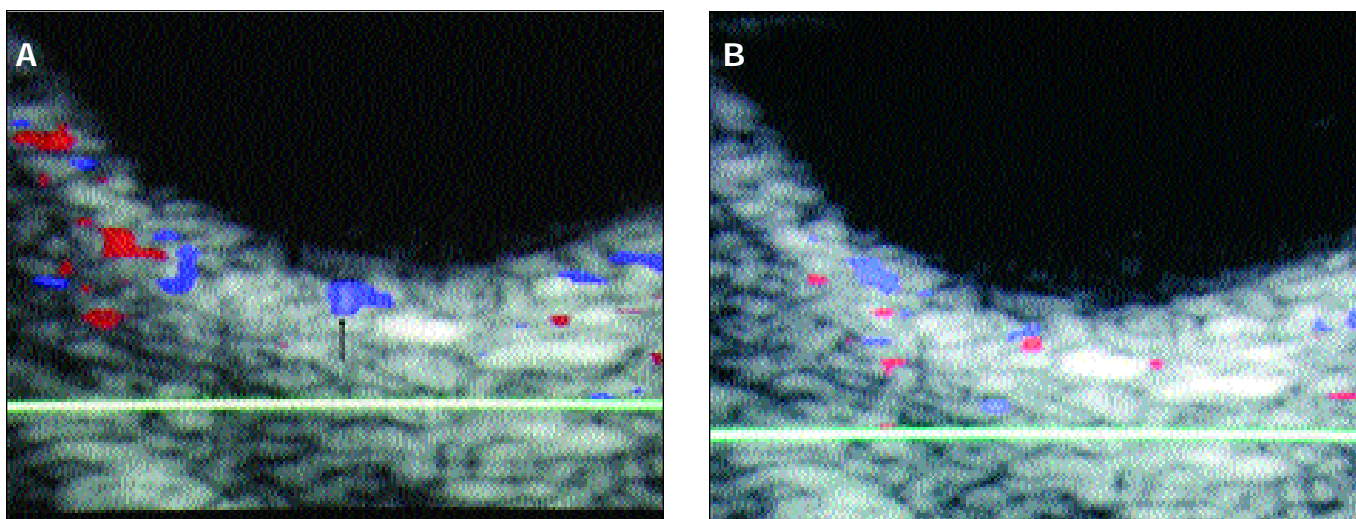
Patient 3. (A) Color Doppler imaging showed the gaze-evoked prominence of the lesions of venous origin (arrow).(B) Disappearance of the lesions in primary gaze.
